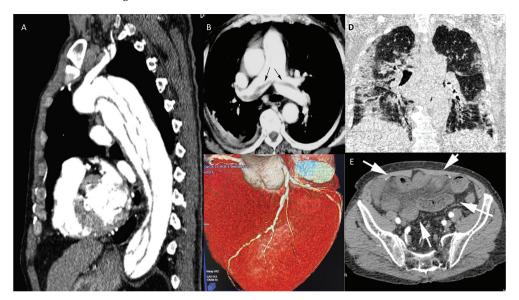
Use of CT in acute heart failure.
